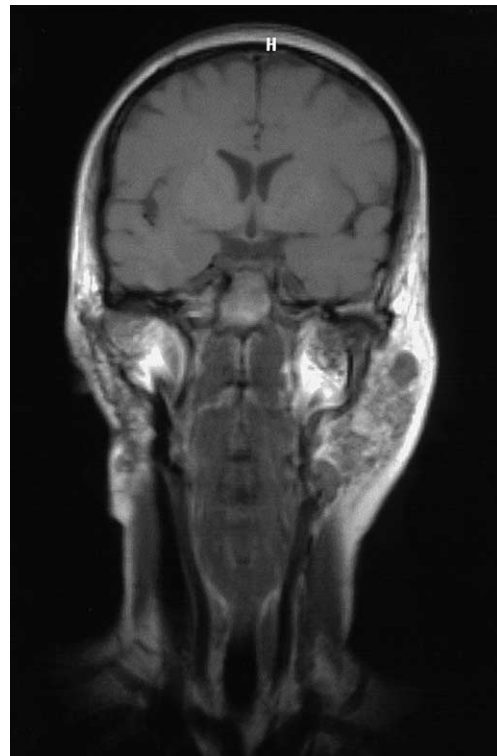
MRI (coronal section) demonstrating ill defined mass within the left parotid gland. No evidence of tumour in the right parotid gland.
